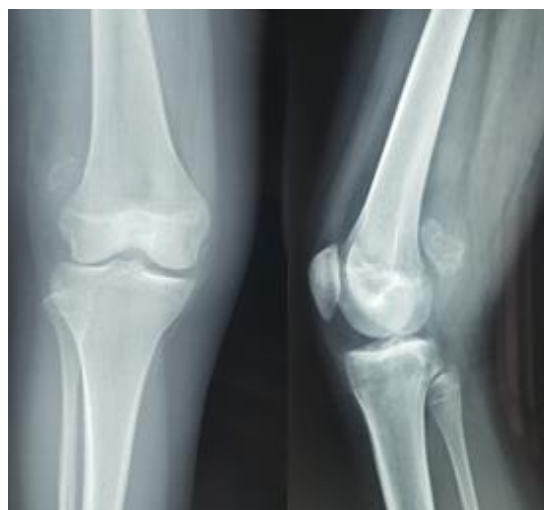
X-ray of the right knee face and profile showing periarticular calcifications of the right knee
